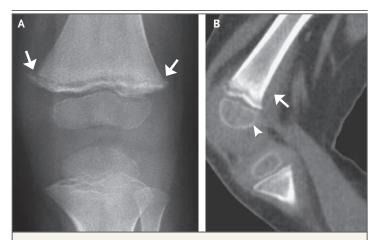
Radiograph and CT of the Femur.
